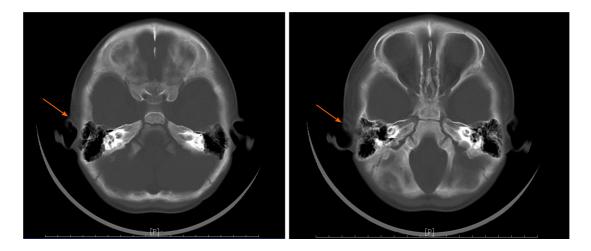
Computed tomography images. A low-density nodular shadow with a size of 2.2 mm × 7.6 mm × 9.1 mm was observed subcutaneously in the right temporal region. CT value was about 1-17 HU, which was uneven after enhancement. It was about 44-46 HU in the arterial phase and 37-70 HU in the venous phase. Orange arrows indicate the fistula.
